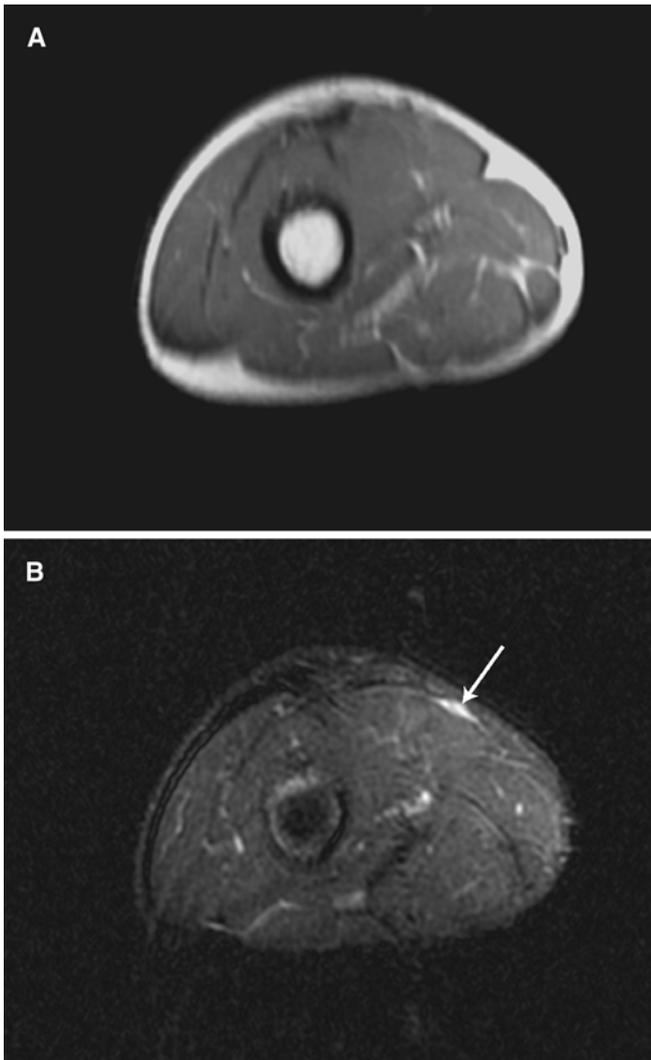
Axial proton density (A) and T2-weighted (B) MR images at the same axial location from a subject with cerebral palsy. The T2-weighted image shows extensive fluid (grade 4) near the transferred rectus femoris tendon (*arrow*)
